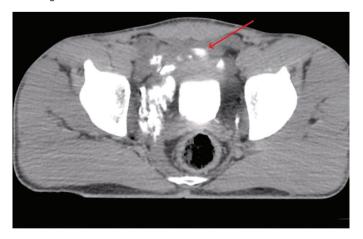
Leakage of contrast into pelvis in abdominal computed tomography scanning
